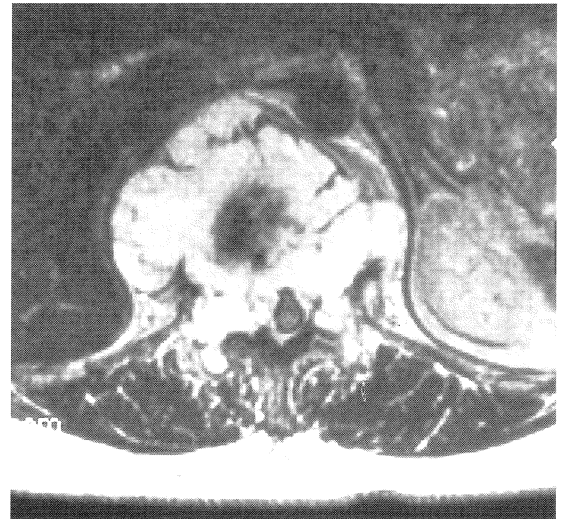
MRI scan of T12 vertebra taken at the same level as Fig 2. T2-weighted axial image shows a large expansile lesion arising from the T12 vertebral body. Note compression and moulding of the spinal cord. The extent of the lesion is more clearly delineated than on CT. The areas of linear signal void represent thickened trabeculae.
